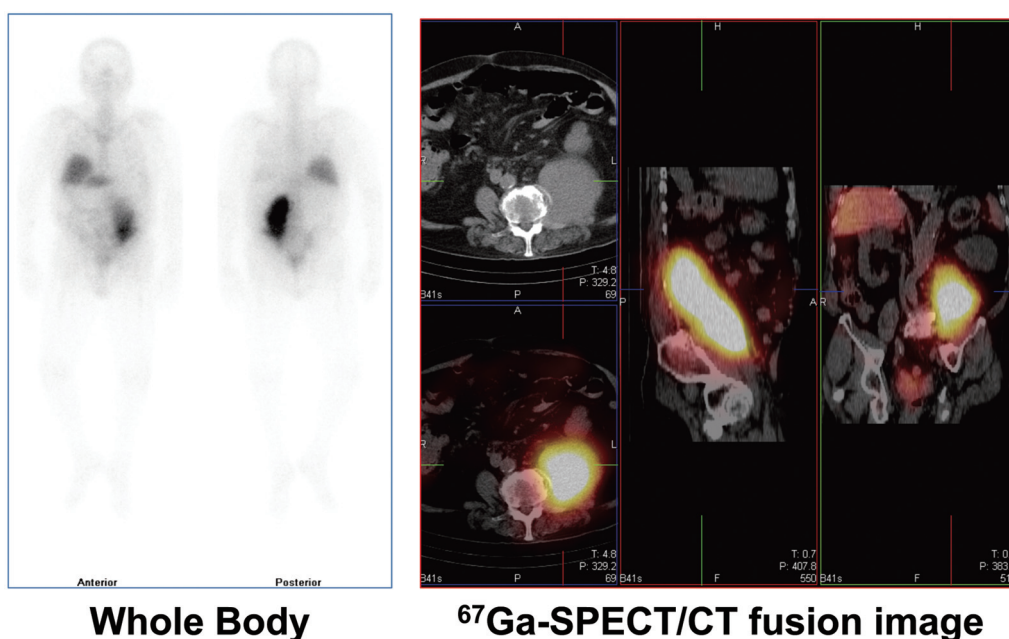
Representative case of PTLD after HTx; detected by ⁶⁷Ga scintigraphy
